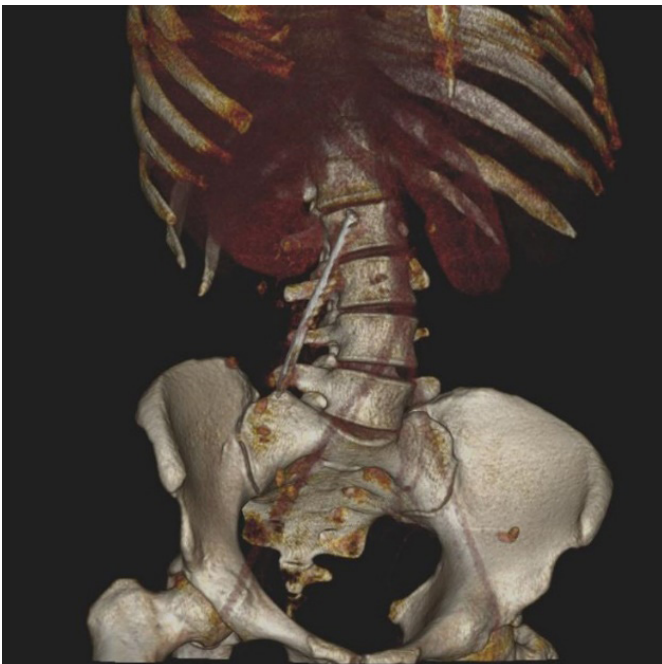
Abdominal three dimensional computed tomography of patient
